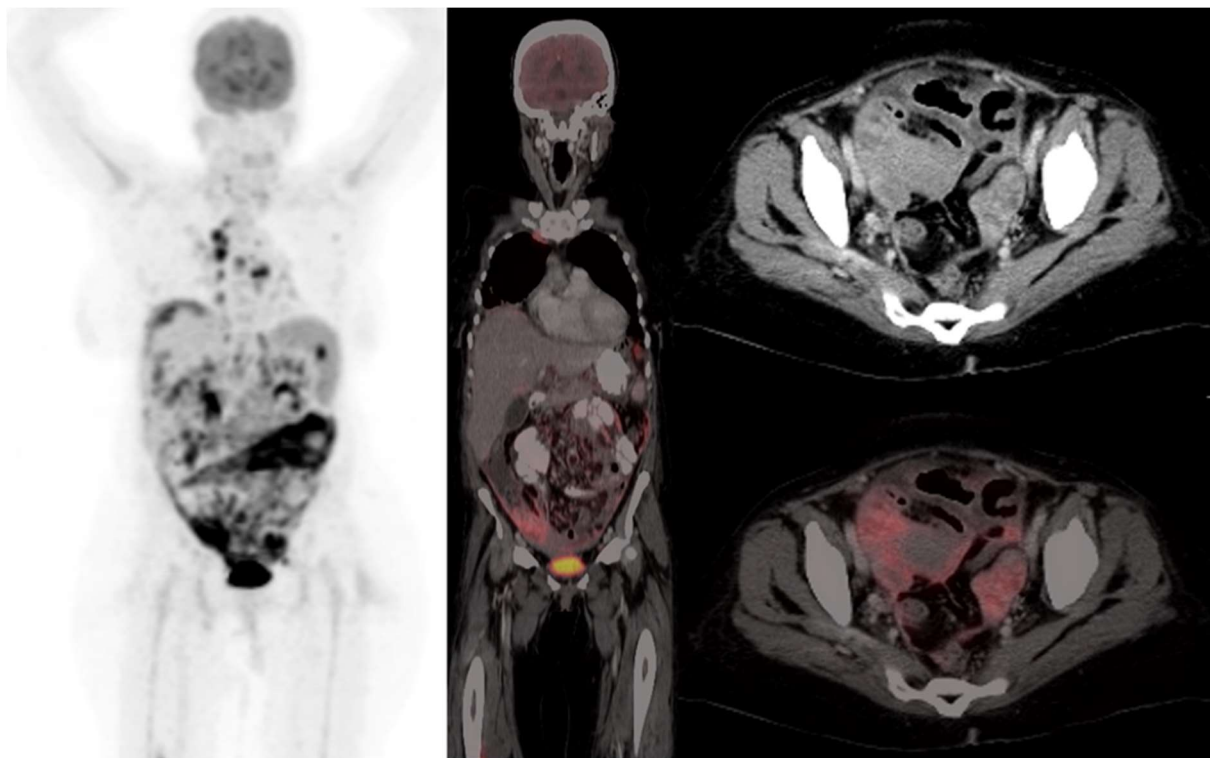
FDG PET/CT images of a middle-aged woman with pulmonary tuberculosis. On account of abdominal symptoms and associated ascites, FDG PET/CT was obtained to evaluate for extra-pulmonary sites of disease involvement. In addition to the FDG-avid chest lesions, there is thickening of peritoneum with intense FDG uptake suggestive of concomitant peritoneal tuberculosis. Ascites and abdominal symptoms resolve with anti-tuberculous treatment. This case highlights the role of FDG PET/CT to evaluate the whole-body burden of the disease.
